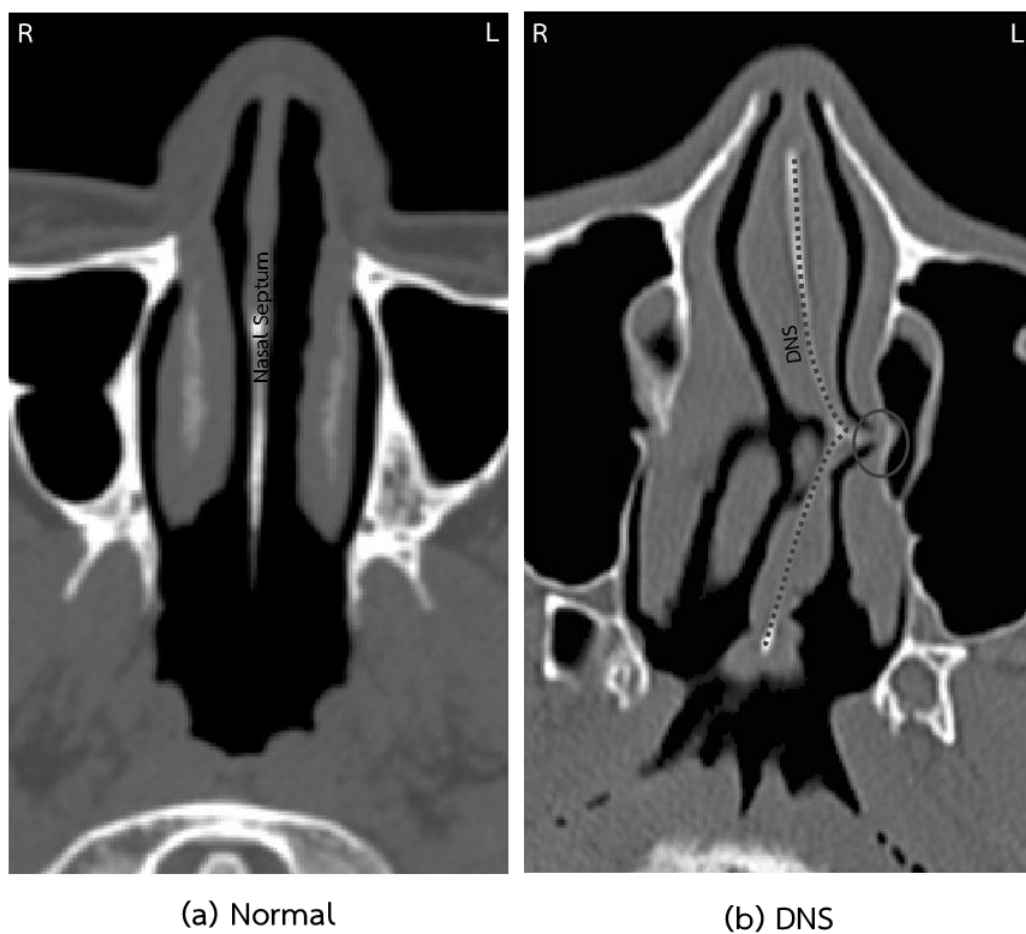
Axial CT images compared between healthy nasal cavity (a) and leftward DNS (b). Straight nasal septum is presented in healthy nose. Deviated nasal septum (dotted line) is virtually collapsed (circle) shown in DNS nose.
